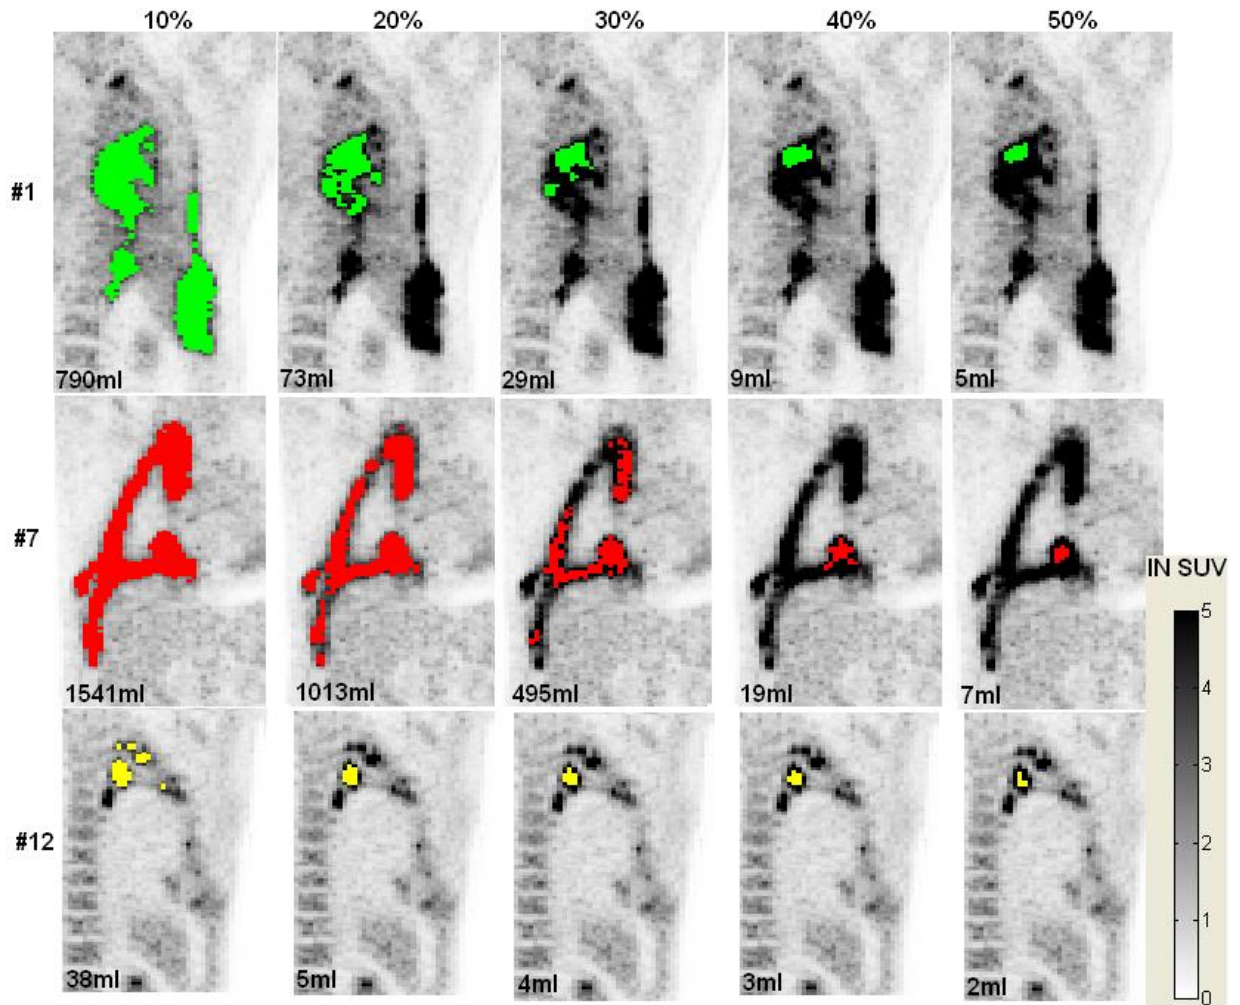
Background Corrected SUV_{max} Segmentation Method
